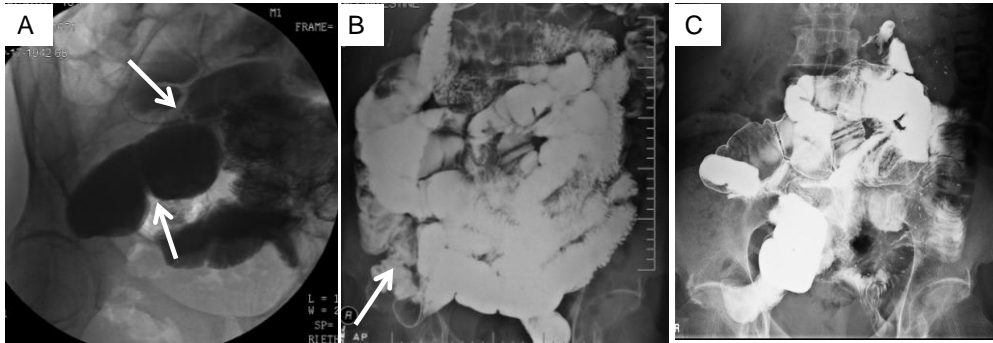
Small bowel radiographs. Arrows note areas of obstruction. (A) Before therapy incomplete SBO due to adhesions visualized by X-ray showing dilation of the proximal mid ileum. (B) Mid treatment: mild stricture at the terminal ileum with no other small bowel abnormalities. (C) Post treatment: normal small bowel series.³
